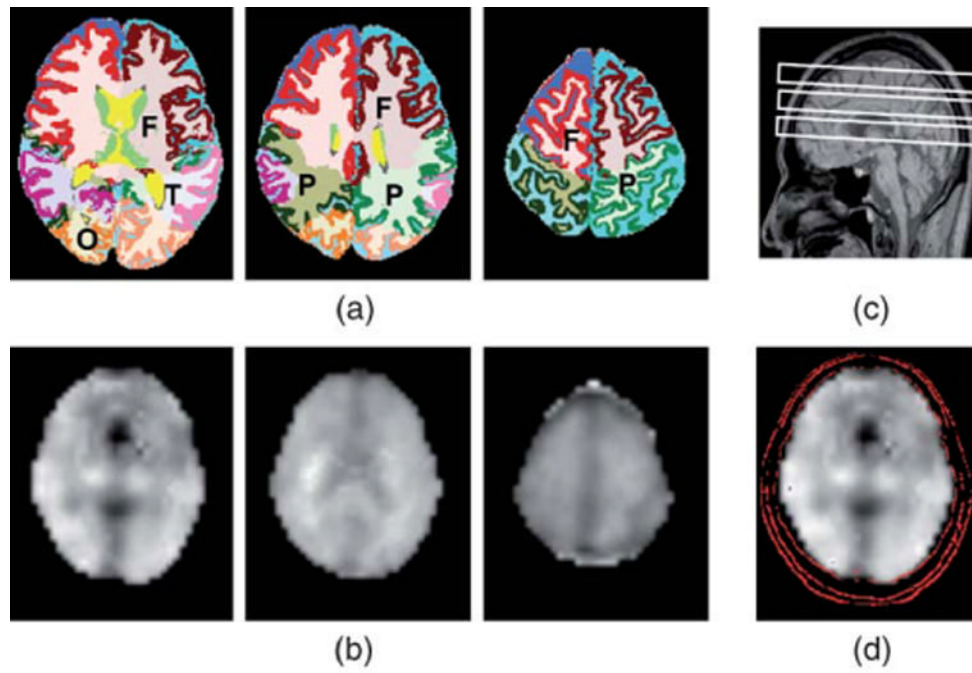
A, Segmented MRI showing frontal (F), parietal (P), temporal (T), or occipital (O) lobe. WM, GM, and CSF were rendered with different colors; B, Transaxial NAA images; C, A sagittal scout MRI indicating slice positions; D, A contour plot showing alignment of MRI and MRSI.
